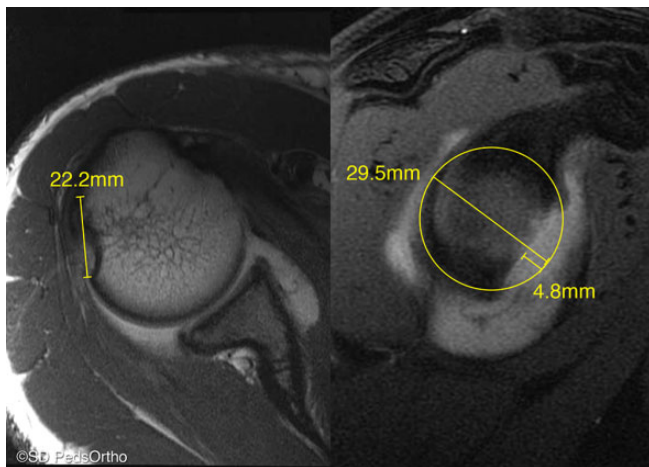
Measurement of “on-track” and “off-track” Hill-Sachs lesions according to Di Giacomo et al.⁹ Measurement of the Hill-Sachs track on the T1-weighted axial image (left) and measurement of the glenoid index on the T1-weighted sagittal image (right). Images courtesy of SD PedsOrtho.
